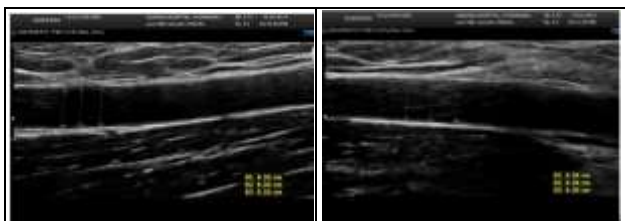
Ultrasonic Image of Rt. Brachial Artery at Baseline and One Minute after a Hyperaemic Stimulus*
